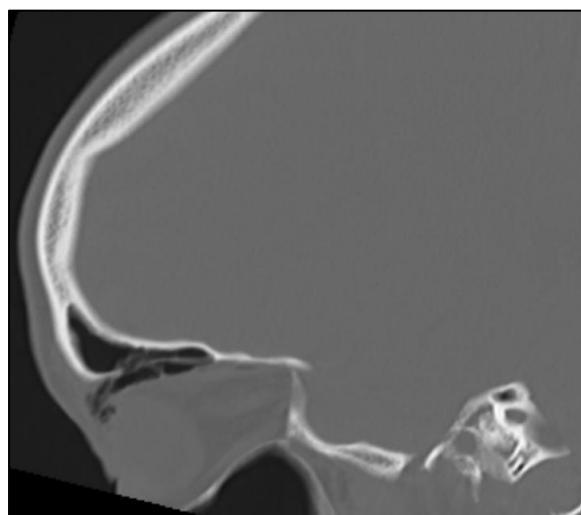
Sagittal view of the CT bone window showing intraorbital air.
